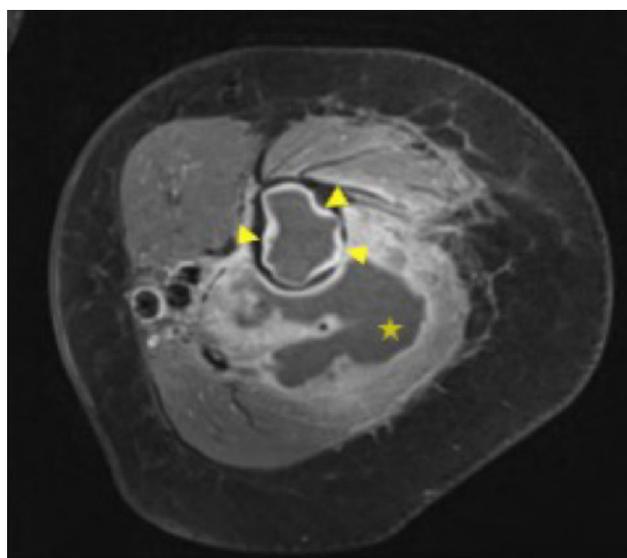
T1-weighted axial and coronal views with "fat sat" and contrast agent.
